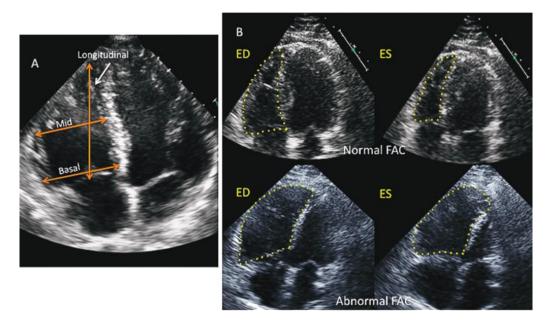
RV dimension and area measurements in the apical 4-chamber view. A, Basal, midcavity, and longitudinal RV dimensions. B, The upper panel shows an RV with normal systolic function and a normal FAC. The lower panel shows a markedly dilated RV with decreased function and an abnormal FAC. The calculation of percentage FAC is [(area at ED – area at ES)/area at ED)] \times 100. ED: end-diastole; ES: end-systole; FAC: fractional area change; RV: right ventricle.
